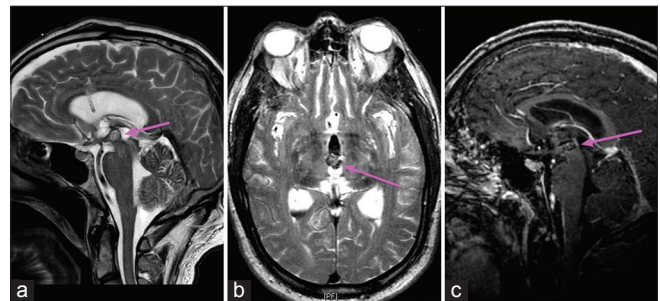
Case #2 MRI showing typical appearance of cavernoma in the 3rd ventricle. [(a) Sagittal T2, (b) Axial T2, (c) Sagittal T1 with contrast]
